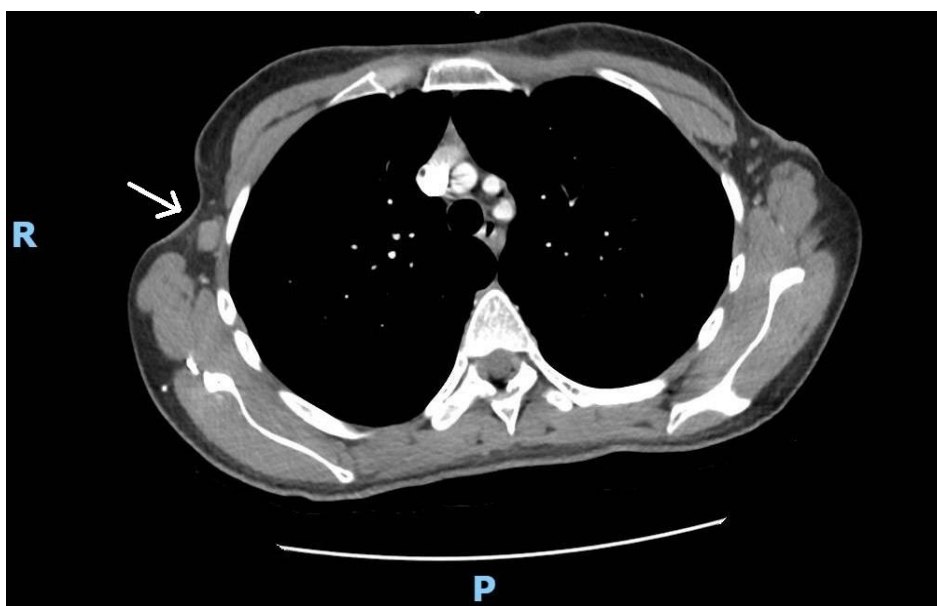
CT scan (axial) showing an enlarged lymph node.
